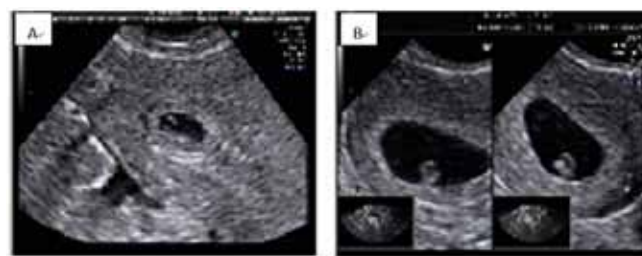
(A): Transvaginal ultrasound of uterus showing an intrauterine gestational sac of approximately 5+ weeks. (B): Transvaginal ultrasound showing gestational sac with fetal pole in uterus.
